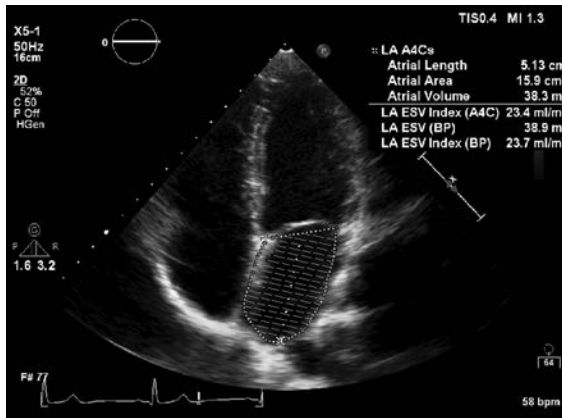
Left atrial volume measurement. Left ventricle volume is measured in the apical 4-chamber view by tracing the inner edge of the atrial border at end-systole. At the mitral annulus, a straight line from leaflet insertion to leaflet insertion is used for this calculation. The area is also traced in the 2-chamber view for a biplane volume calculation.
